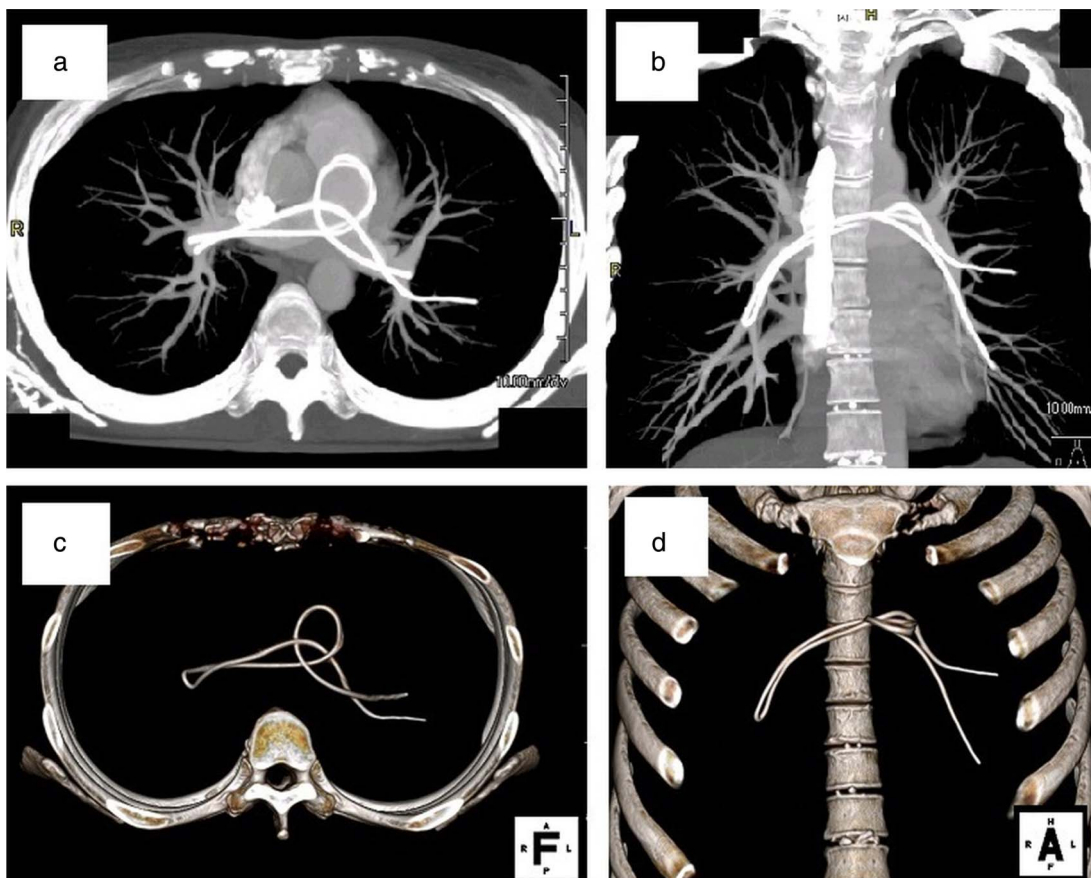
Three-dimensional reconstitution of chest CT revealing the spectacular migration of the central venous catheter into the pulmonary arteries. (A) Axial plane of the maximum intensity projection (MIP) view. (B) Frontal plane of the MIP view. (C) Axial view of the three-dimensional reconstitution of chest CT (3D-CT). (D) Frontal view of the 3D-CT without part of the ribs or spine.
